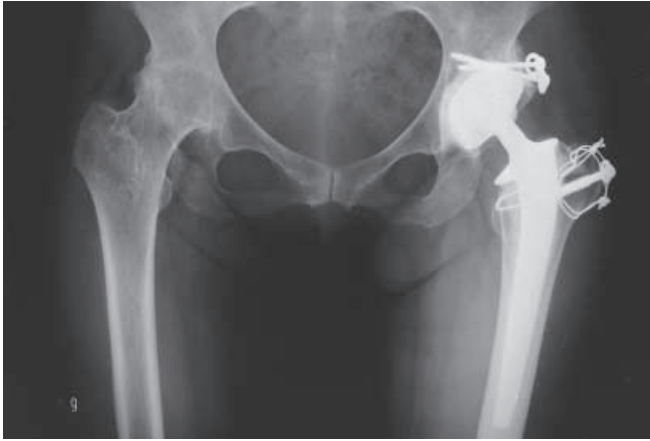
Preoperative radiographs of the hip joints. At age 36, the right hip spontaneously fused in an acceptable position (25° of flexion, 5° of abduction, and no rotation) and gait pain disappeared. At age 42, the patient complained of pain in the left hip joint. Joint destruction was present. Total hip arthroplasty was performed at another institution about 1 year later
